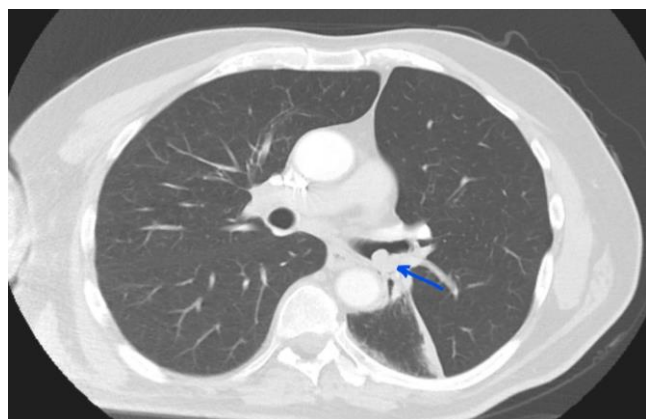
Tumor in the distal left main bronchus on Thorax CT
